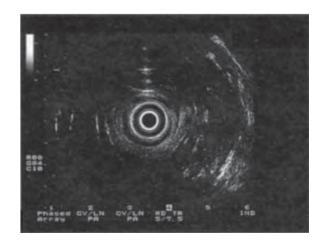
Anal ultrasound showing an anterior external sphincter defect. The crescentic echogenic band anteriorly is generated by the examiner's finger in the vagina.
